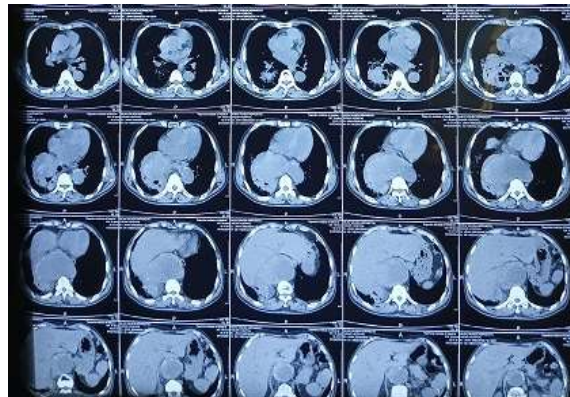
CT – Thorax Mediastinal Window
